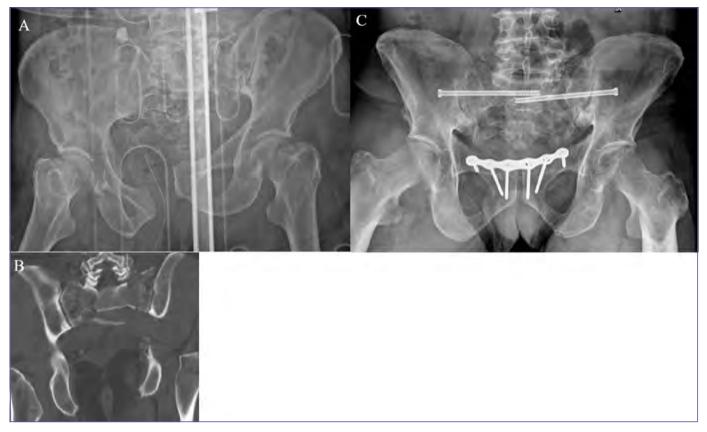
A) a Tile C3 fracture in shock room; B) coronal reconstructions of CT scans where a spino-pelvic disjunction is observed (sacral U-fracture); C) definitive treatment with pubic plate, bilateral sacro-iliac screws, and spino-pelvic fixation.
